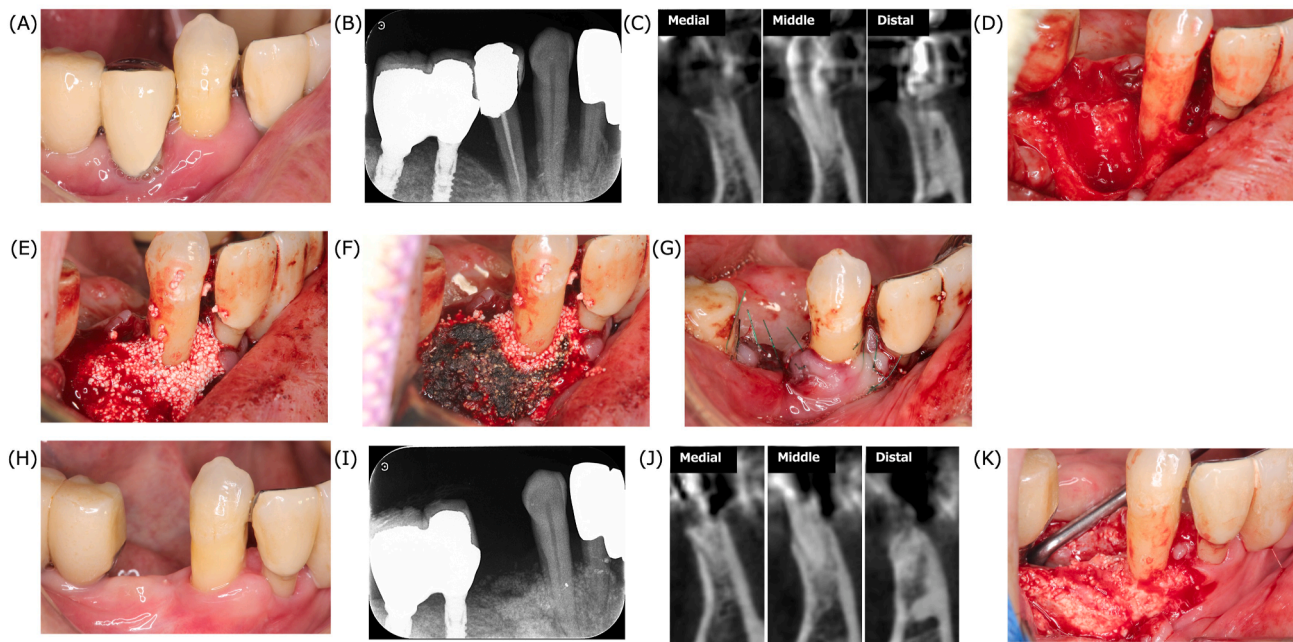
Carbon dioxide laser-assisted bone regenerative therapy (LBRT) case. (A) Intraoral photograph showing teeth 43 and 44 with severe periodontal destruction. (B) Periapical radiograph showing that the bone defect around tooth 44 is continuous with that on the distal aspect of tooth 43. (C) Coronal cone-beam computed tomography images of tooth 43 showing narrow and deep two-to three-wall bone defects on the mesial aspect and wide and deep one-to two-wall defects on the distal aspect. (D) The distal bone defect of tooth 43 was connected with the extraction socket of tooth 44. The mesial and distal bone defects were separated by the residual buccal bone. (E) Blood-mixed carbonated apatite (CA) has been filled in the bone defect. (F) Blood clot formed on the grafted CA after carbon dioxide laser irradiation. The formed blood clot effectively stabilized the bone graft material, similar to a collagen membrane. (G) The wound was closed with simple sutures using 5-0 nylon. (H) Pocket depth at all sites was <3 mm. No complications related to carbon dioxide laser-assisted bone regenerative therapy were observed. (I) Periapical radiograph showed that the bone defect had been filled with regenerated bone. (J) Coronal cone-beam computed tomography images showed bone fill in the area of the one-wall defect. (K) Intraoperative photograph during re-entry surgery showed dramatic bone regeneration without blackened fibrin clots.
